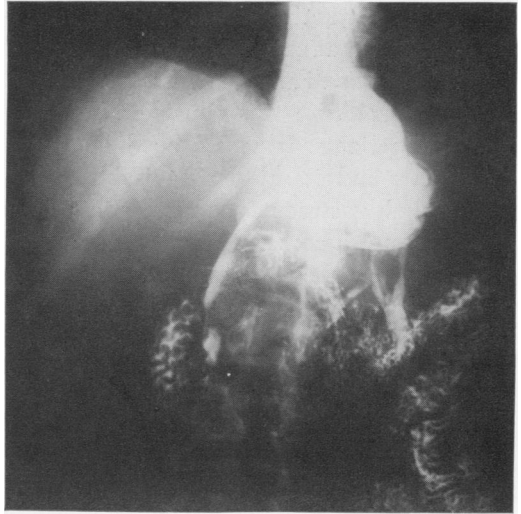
Case 3. X-ray of gastrograffin meal demonstrating leakage of media from gastric remnant by multiple tracts.
